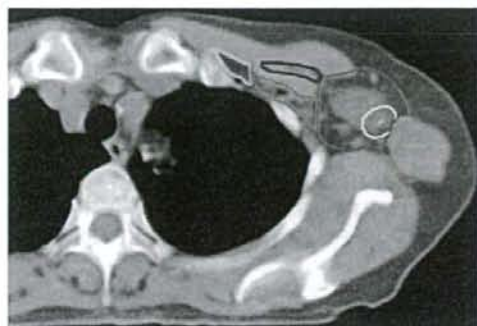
An example of computed tomography image showing the axillary lymph node region. Level I is shown in red, level II in pink, level III in light blue, Rotter's node region in blue, surgical clip in green, and the sentinel lymph node region in yellow.
